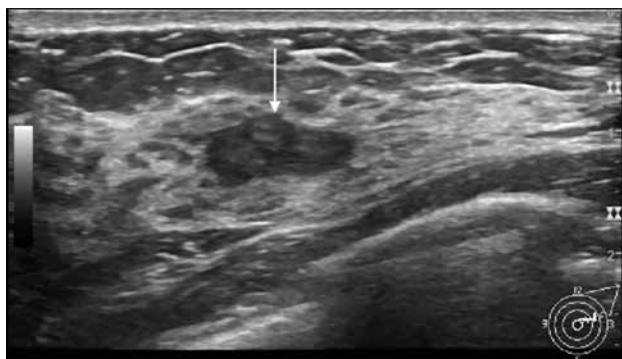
The targeted papilloma was identified on ultrasonography as a hypoechoic solid lesion (arrow) in the 2 o'clock position of the left breast in a 40-year-old female patient.
